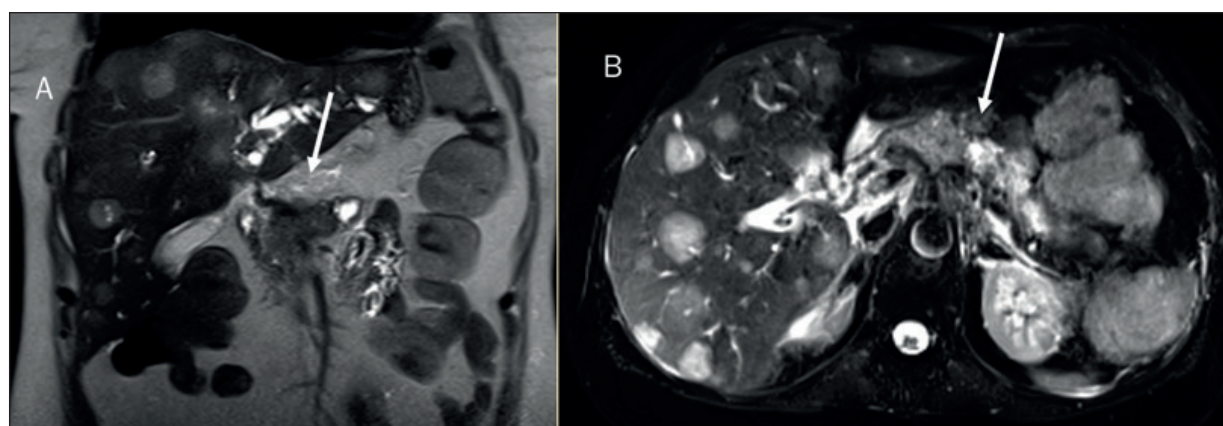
The same patient of Figure 5, assessed on MRI (in A T2-W sequence in coronal plane and in B T2-W FAT Suppressed sequence in axial plane). The PC is not as well evident as in CT study.
